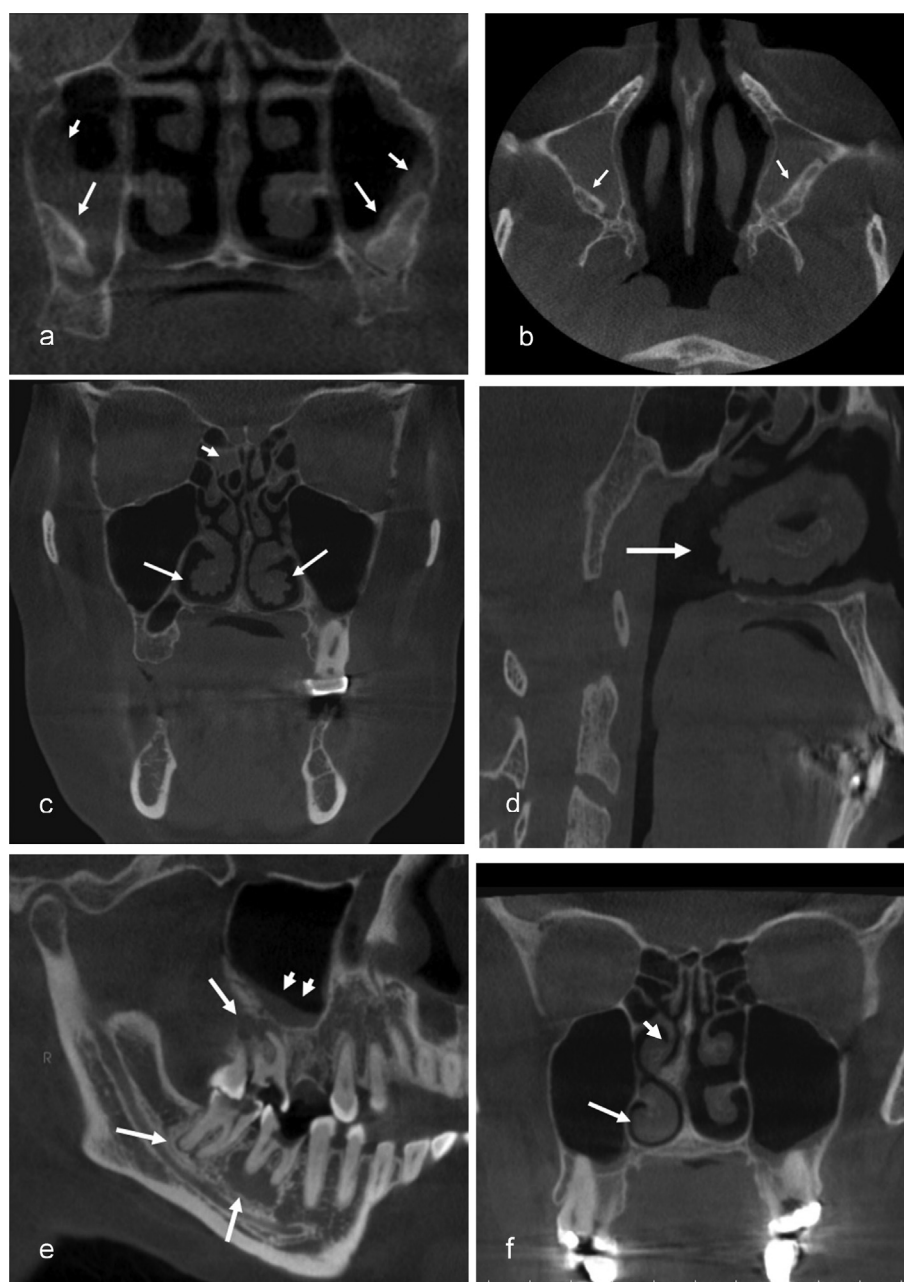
(a) Coronal CBCT slice showing mucosal thickening (short arrows) and calcification (long arrows) in maxillary sinus. (b) Axial CBCT view showing opacification of maxillary sinus (arrows). (c) Coronal CBCT slice showing irregular or serrated right and left inferior nasal concha (long arrows) with partial opacification of ethmoid sinus (short arrow). (d) Sagittal CBCT view of the right serrated concha. (e) Cropped reformatted panorama showing polypoid mucosal thickening of maxillary sinus (double arrows) and periapical radiolucency related to mandibular and maxillary left second molars (short arrow). (f) Coronal CBCT slices showing deviated nasal septum and hyperplasia of nasal conchae at right side (long arrow).
